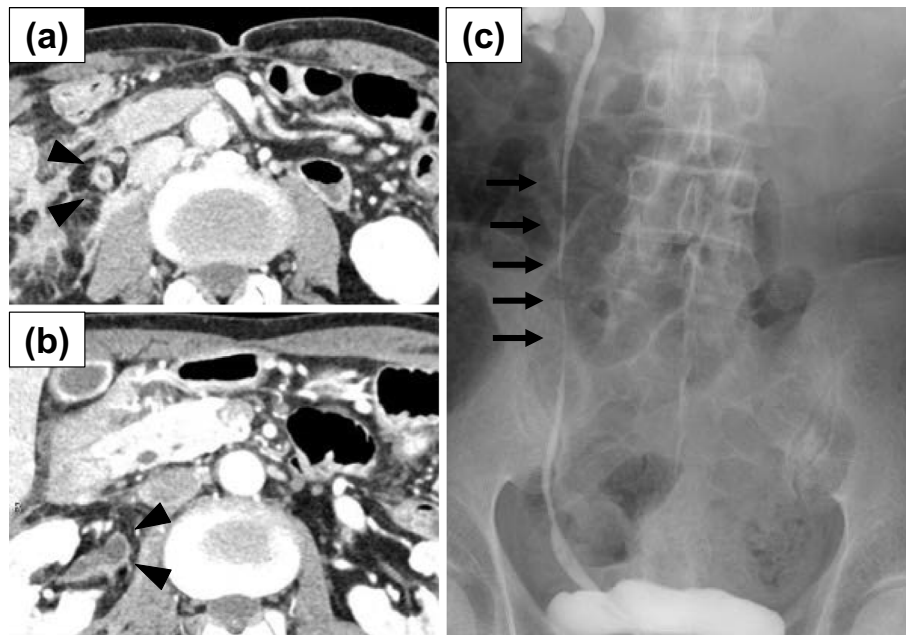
Appearance of the ureteral stenosis at three months after initial visit. (a), (b) Abdominal computed tomography showed right hydronephrosis and wall thickening of the right ureter (arrowheads). (c) Retrograde urography showed irregular ureteral stenosis (arrows).
